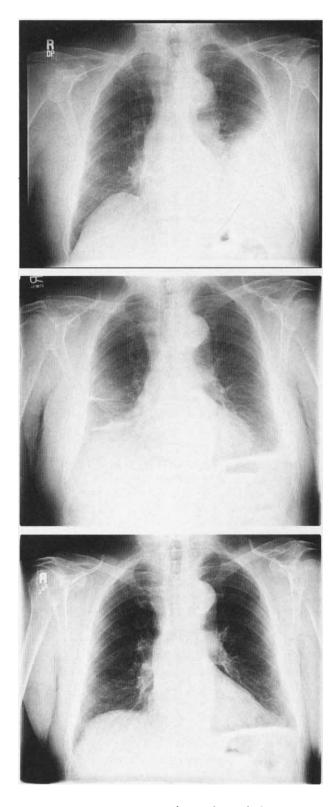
Top: Posteroanterior chest radiograph demonstrating a large left pleural effusion without obvious parenchymal abnormalities. Center: Posteroanterior chest radiograph demonstrating a left pleural effusion with new right pleural thickening and/or effusion. Bottom: Posteroanterior chest radiograph demonstrating near-complete resolution of the bilateral pleural abnormalities.
